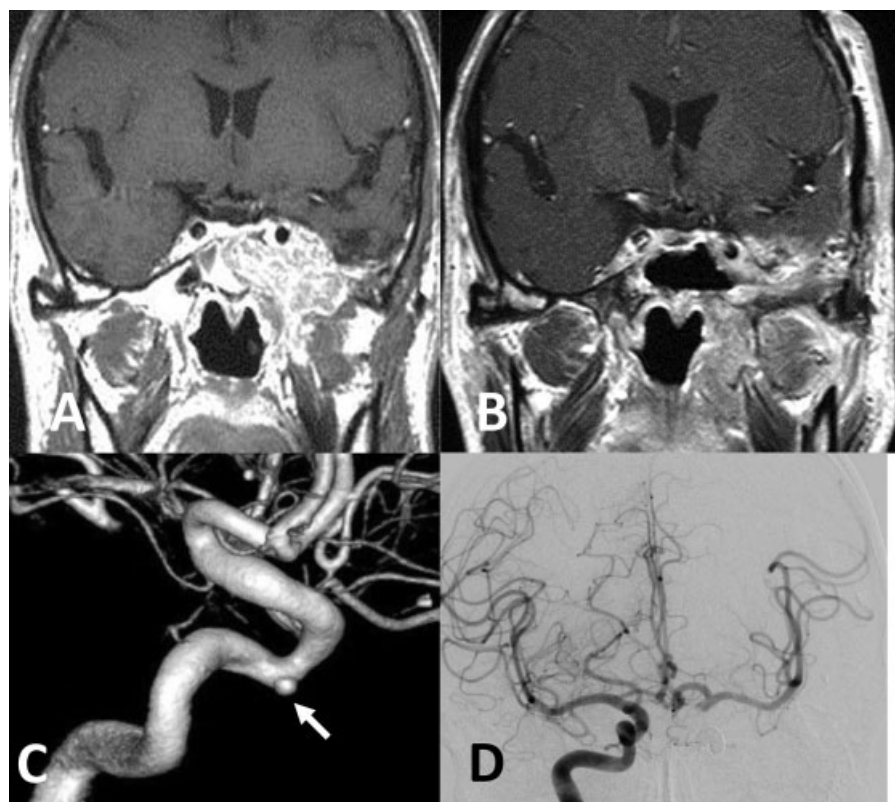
(A) Coronal T1-weighted magnetic resonance image with gadolinium (MRI-Gd) after stereotactic radiosurgery revealed tumor recurrence in the cavernous sinus and the left infratemporal fossa surrounding the left internal carotid artery (ICA). (B) MRI-Gd after stereotactic radiosurgery and stereotactic radiotherapy demonstrated an almost disappearance of the tumor. (C) Left internal carotid angiogram demonstrated a small aneurysm at the left cavernous ICA (arrow). (D) Right internal carotid angiogram after the endovascular treatment showed enough collateral flow via the anterior communicating artery.
